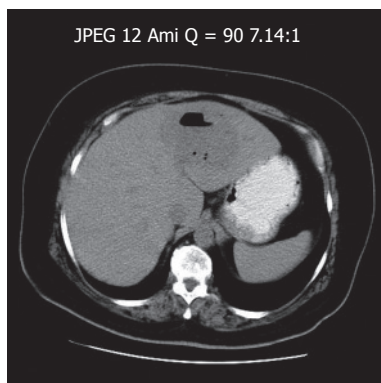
Contrast enhanced CT scan showing a low-density area with gas and fluid, measuring approximately 8.5 cm x 7.0 cm, consistent with left-sided intra-hepatic abscess.
